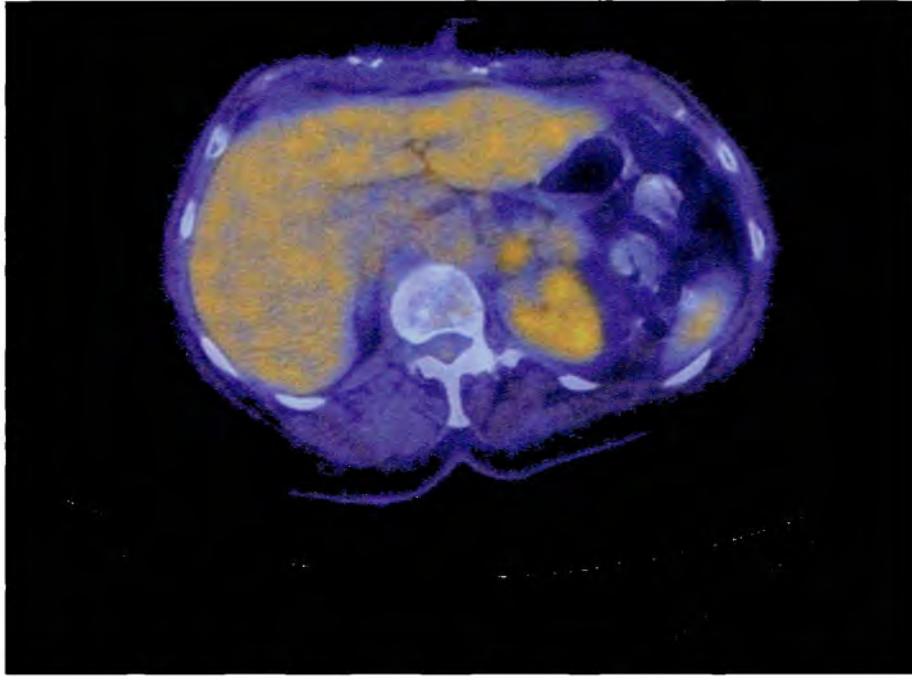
Hypermetabolic fullness of the left adrenal gland demonstrates FDG avidity greater than normal adjacent liver parenchyma, which raises concern for malignant involvement.
